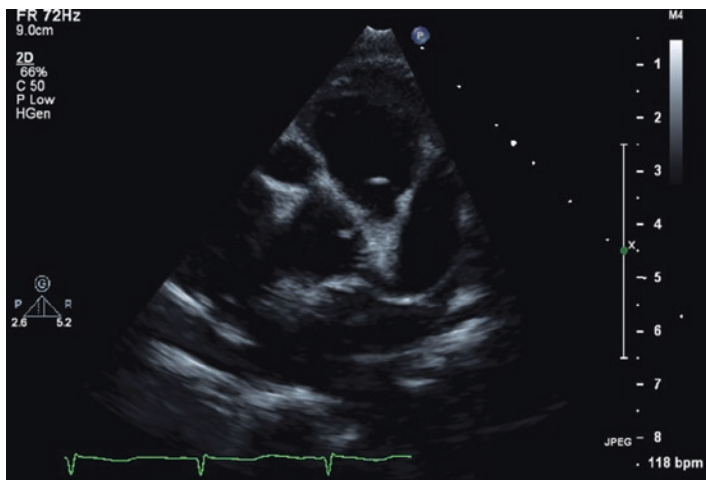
2-D echocardiogram of a 19-month-old male with Kawasaki disease demonstrating 0.91 cm (z-score 28.88, normal range: 0.1–0.2) dilation of left anterior descending artery as well as dilation of the proximal RCA
